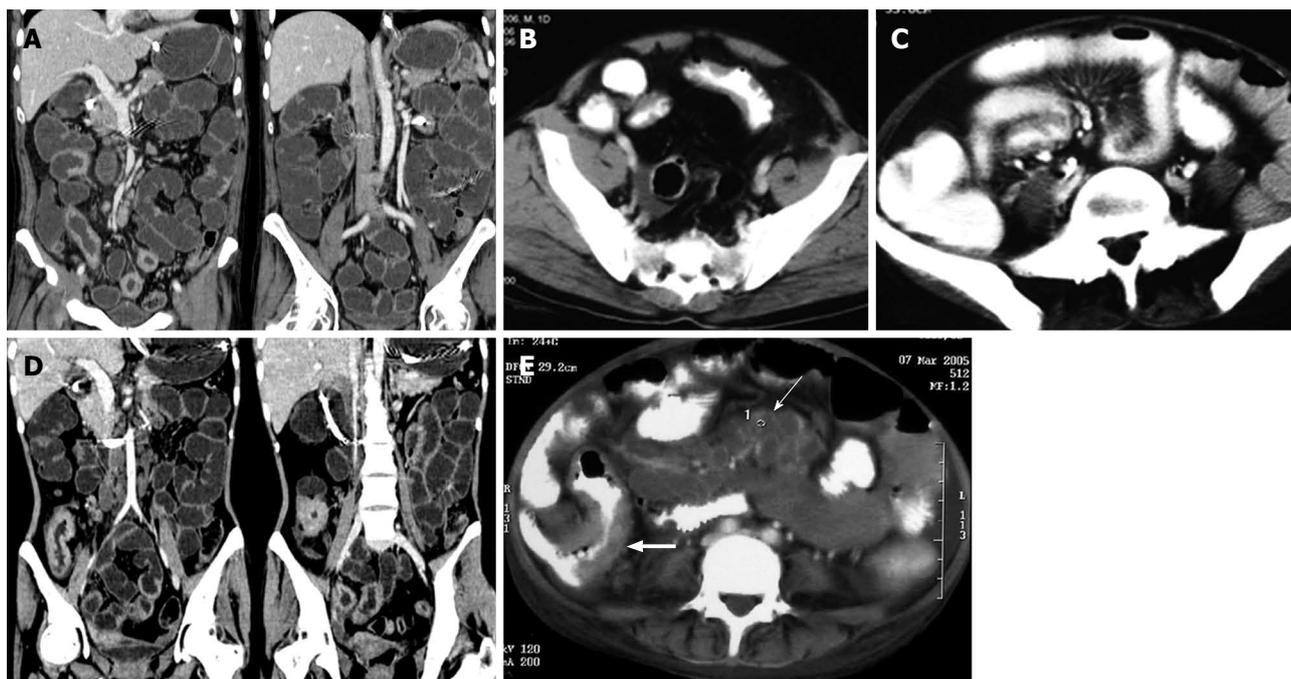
Findings on computed tomography. A: Computed tomography (CT) enteroclysis with negative oral contrast showing mural thickening of ileum with skip areas and sparing of cecum in a patient with Crohn's disease (CD); B: Contrast-enhanced CT scan (CECT) showing asymmetrical mural thickening in ileal loop with deep ulcerations. Note fibro-fatty proliferation of mesentery; C: CECT in another patient with CD showing mesenteric vascular engorgement (Comb sign) with fibro-fatty proliferation of the mesentery; D: CT enteroclysis with negative oral contrast showing contiguous mural thickening of the terminal ileum and cecum in a patient with tuberculosis (TB); E: CECT in a patient with TB showing mural thickening of the terminal ileum and cecum (thick arrow) with multiple enlarged mesenteric lymph nodes showing central hypoattenuating and peripherally enhancing rims (thin arrow).
